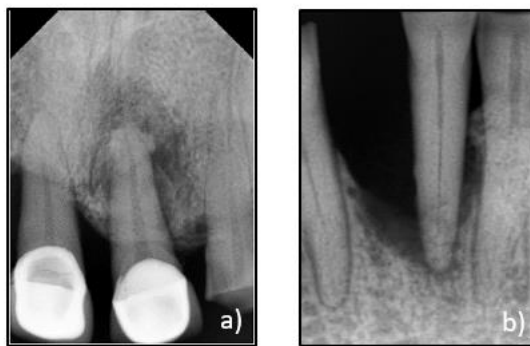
Baseline intra-oral periapical radiograph. a) Radiolucency noted at periapical of 11 & vertical bone loss at mesial of 12 up to $\frac{1}{2}$ of root length. b) Vertical bone loss up to the apex at the mesial of 31.
